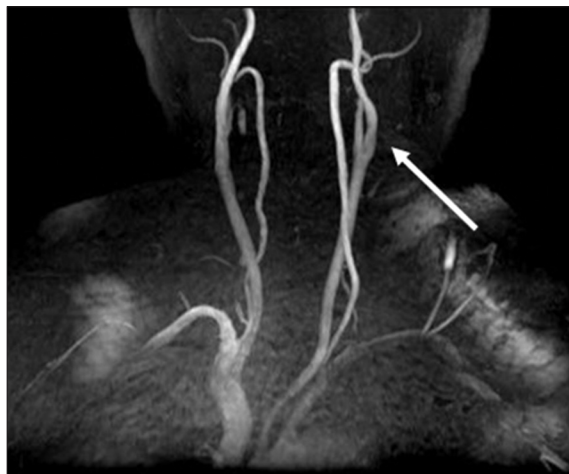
MRI on the day after shunt ligation. Abnormal signals in the IJV completely disappear (arrow). MRI: Magnetic resonance imaging, IJV: Internal jugular vein.
